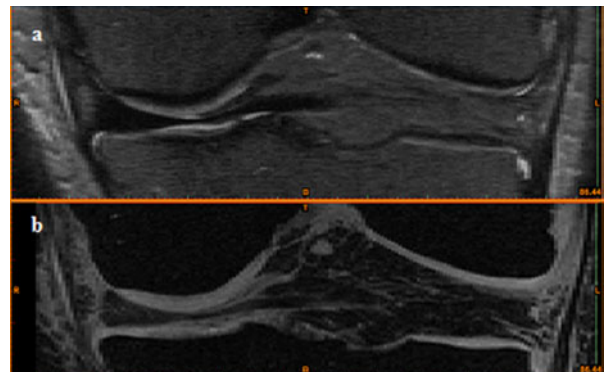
MRI images of the frontal view of the knee joint in (a) CUBE sequence for representation of meniscus and ligament and (b) SPGR sequence for representation of cartilage and bone.
